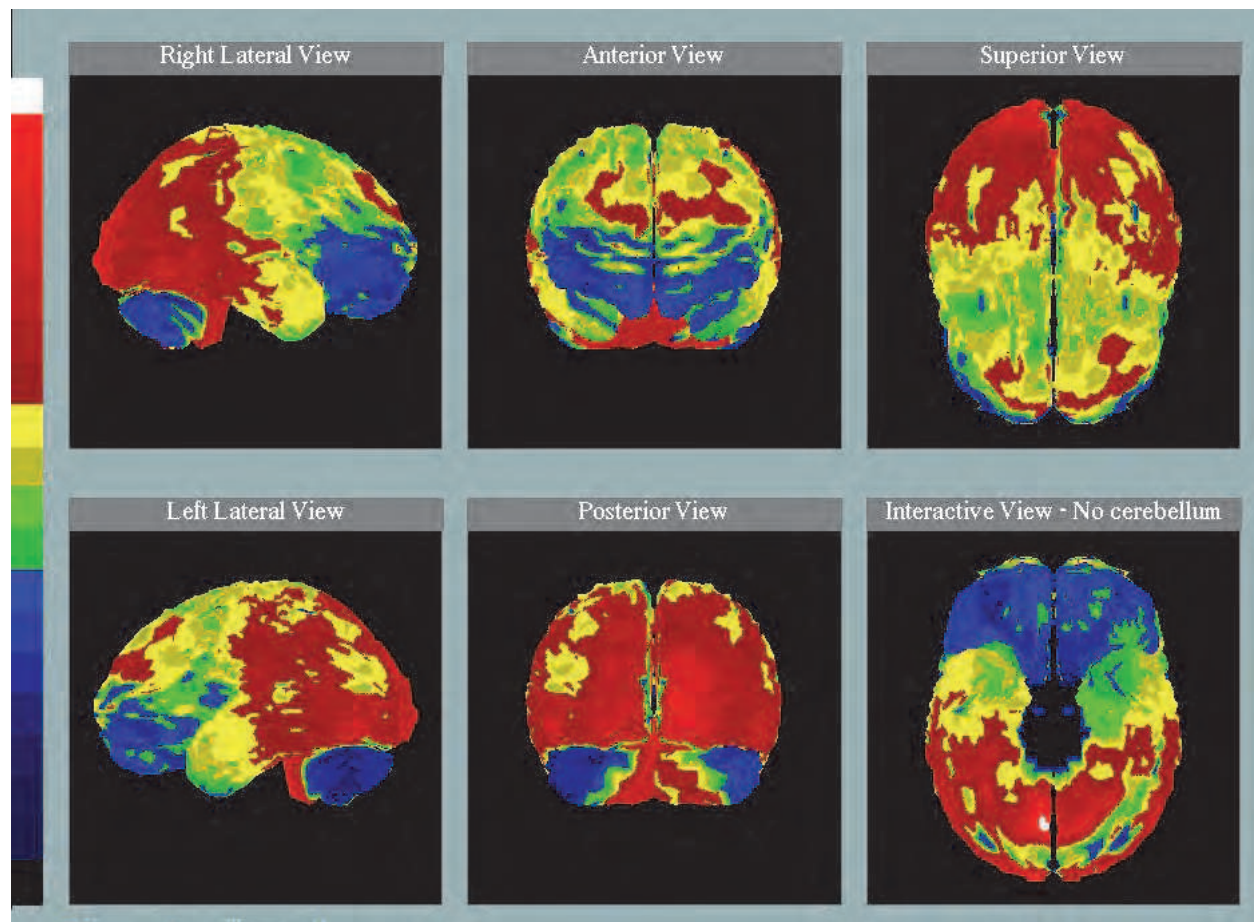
Brain perfusion SPECT study in a patient with Frontotemporal lobar degeneration. Reduced  $^{99m}\text{Tc}$ -HMPAO uptake is observed in frontotemporal cortical areas, more marked in the frontal lobes.
